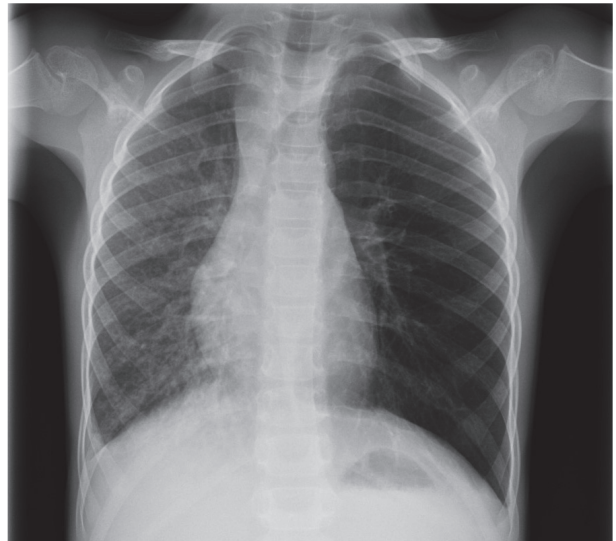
Posteroanterior chest radiography at hospital admission showed hyperinflated left lung with increased lung translucency.
